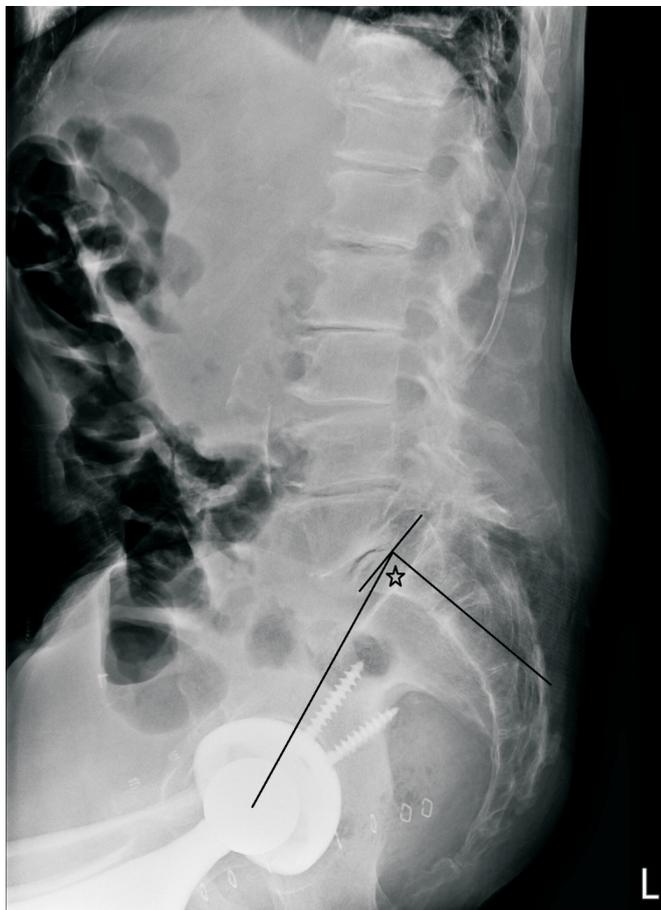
Lumbosacral radiograph revealed severe L5 on S1 spondylolisthesis, and the excessive pelvic incidence is about 78° (star mark).
